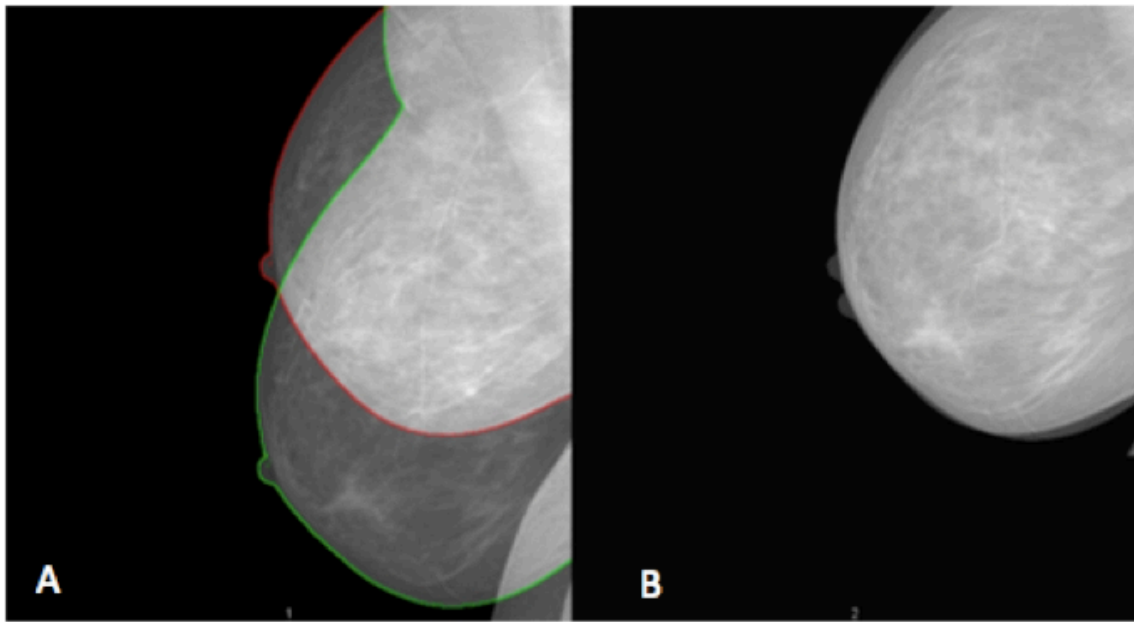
Two mammograms of the same breast were taken 2 minutes apart by the same radiographer. In Frame A, the mammograms were superimposed to show the difference in breast placement in the mammography machine. In Frame B, the two images were digitally aligned to the image showing the smallest breast size (outlined with red in Frame A) prior to density measurement
